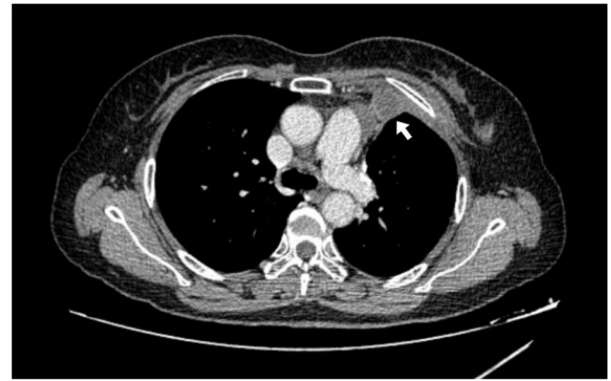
Chest CT scan 2 months after chemoradiation. The white arrow indicates nodular pleural thickening.
